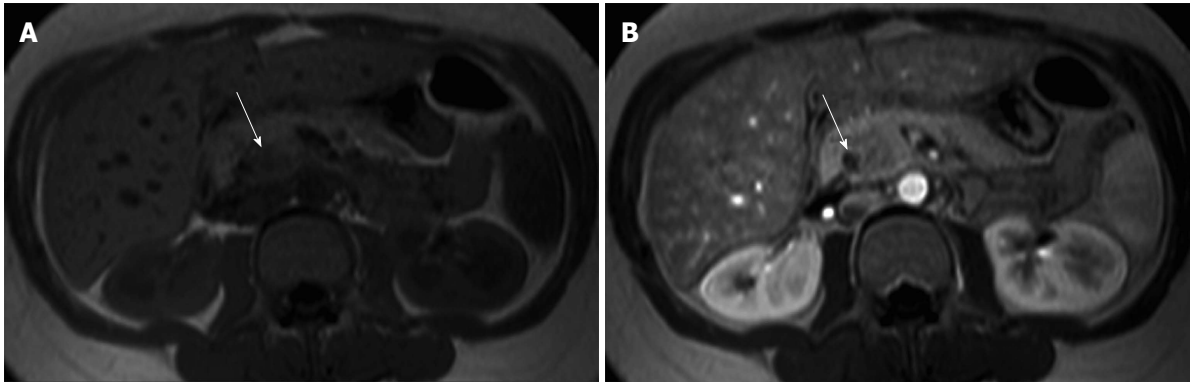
Acute pancreatitis. Axial in-phase (A) T1-weighted GRE image and arterial phase (B) fat-suppressed T1-weighted GRE image (B) in a patient with elevated amylase. There is a nodular area in the uncinate process showing mild T1-weighted hypointensity due to edema, however showing arterial enhancement (arrow, B) and with preservation of marbled pancreatic texture. This was compatible with focal acute pancreatitis. GRE: Gradient echo.
